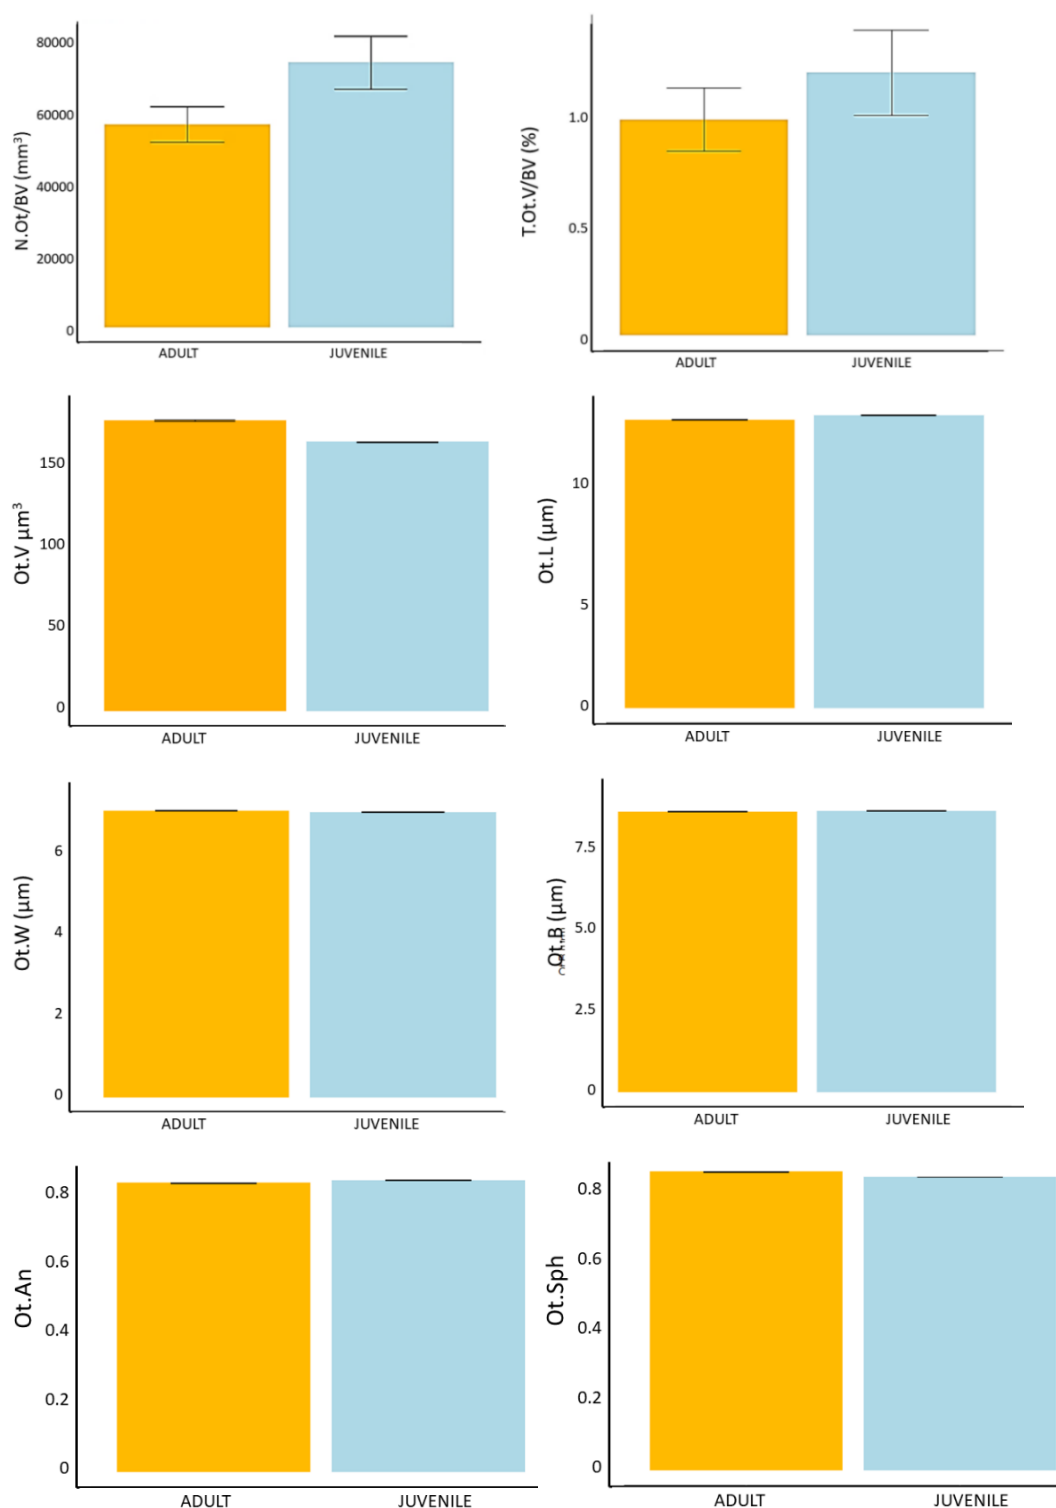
Effect of age on osteocyte network measured using μ CT imaging.
